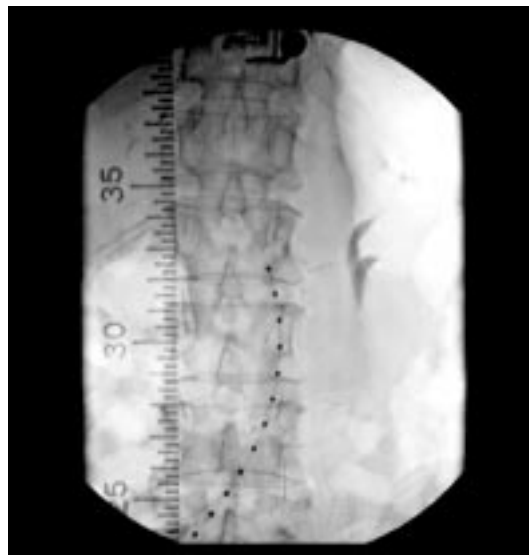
Distortion corrected fluoroscopy image. This image represents the intra-operative scene. It is used, along with the 2D-3D registration algorithm and the pre-operative CT volume, to provide information on the amount of spinal deformation which has occurred between the pre-operative image and the intra-operative scene.
